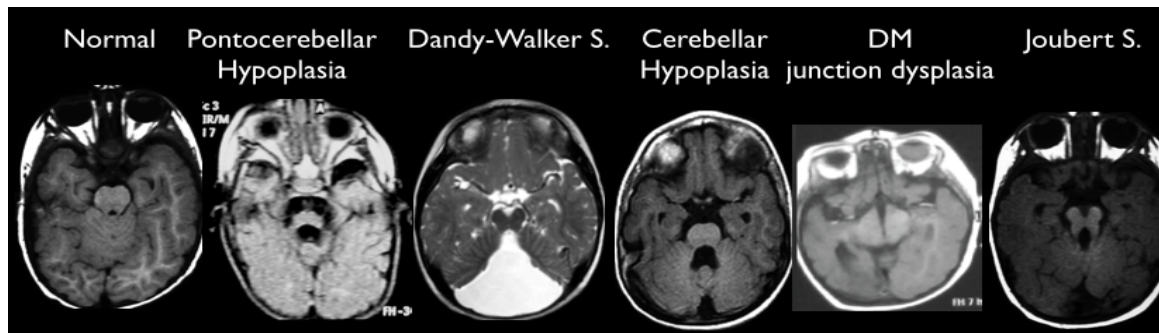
Classification of cerebellar and hindbrain SBDs according to brain MRI appearance.
